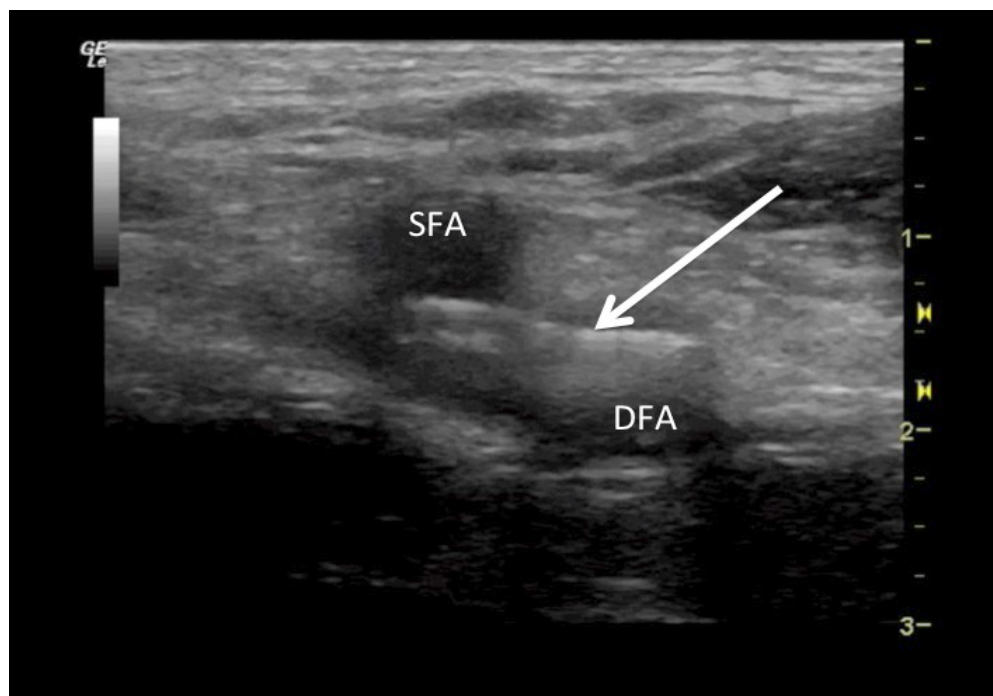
Linear foreign body (arrow) within the femoral artery just distal to the bifurcation of the superficial femoral artery (SFA) and the deep femoral artery (DFA), consistent with retained needle, as seen on point-of-care ultrasound.
